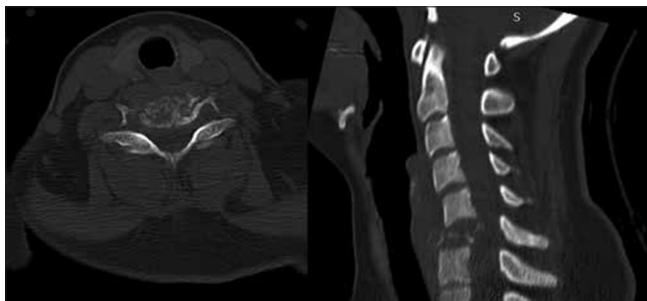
Computed tomography scan of cervical spine shows collapse of the C6 body with posterior subluxation of C5 vertebrae
